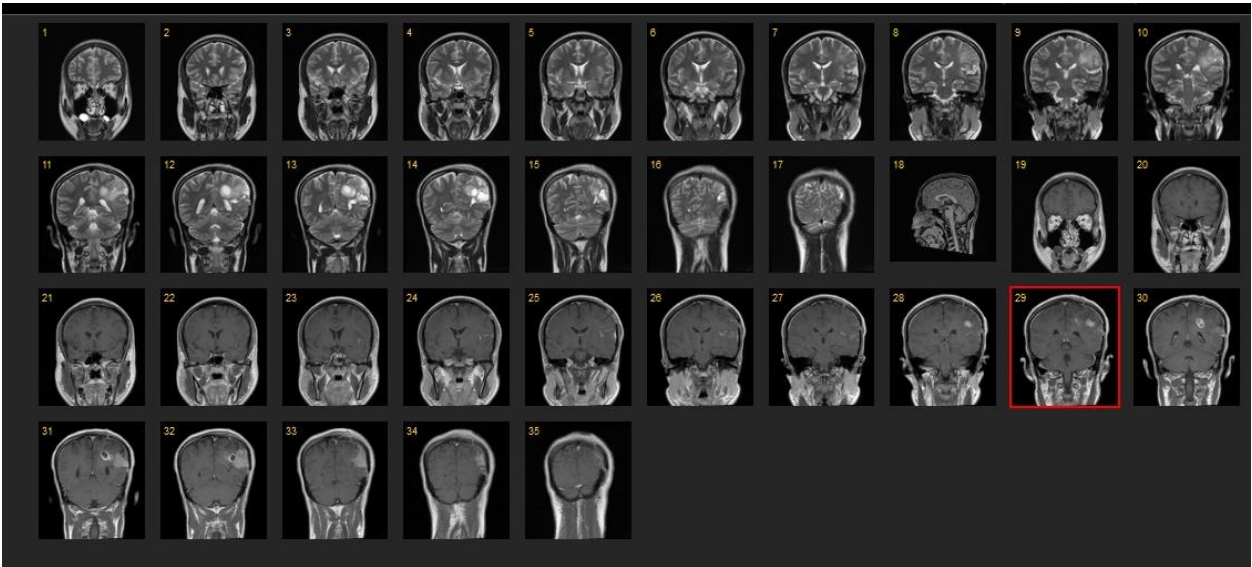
MRI of the Brain with Contrast (Coronal View)
